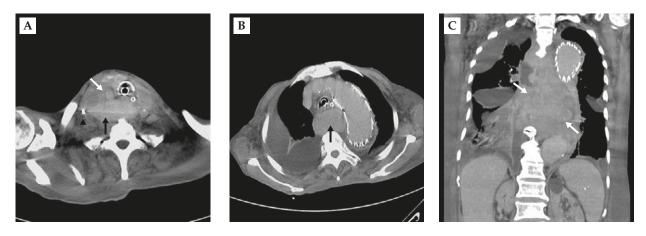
(*A*) Non-contrast computed tomography revealed a right parapharyngeal (white arrow) and upper mediastinal hematoma (black arrow) with central venous catheter in situ (arrowhead). The trachea and esophagus were displaced to the contralateral side. (B) Horizontal and (C) coronary contrast computed tomography showed a huge middle mediastinal hematoma (arrows) without evidence of extravasation of aortic aneurysm with metallic stent.
